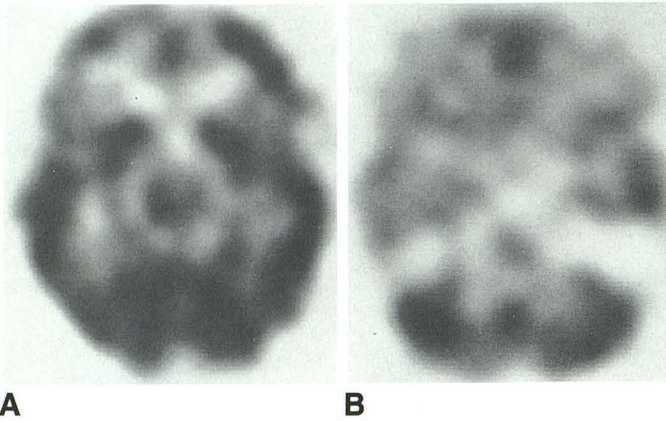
Tc-99m HMPAO SPECT images obtained after initial arteriogram.
